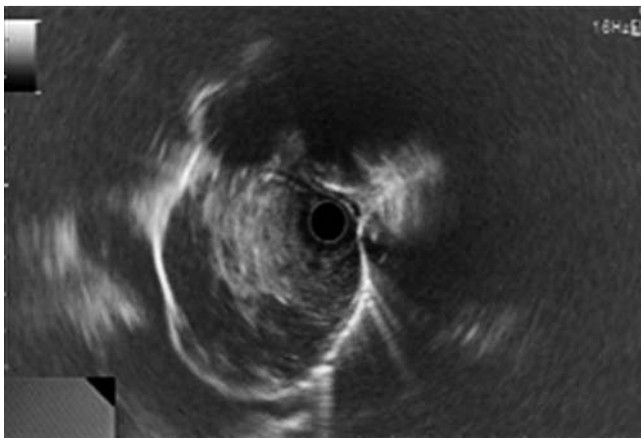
Endoscopic ultrasound image showing a solid lesion with intraluminal and extraluminal growth.
